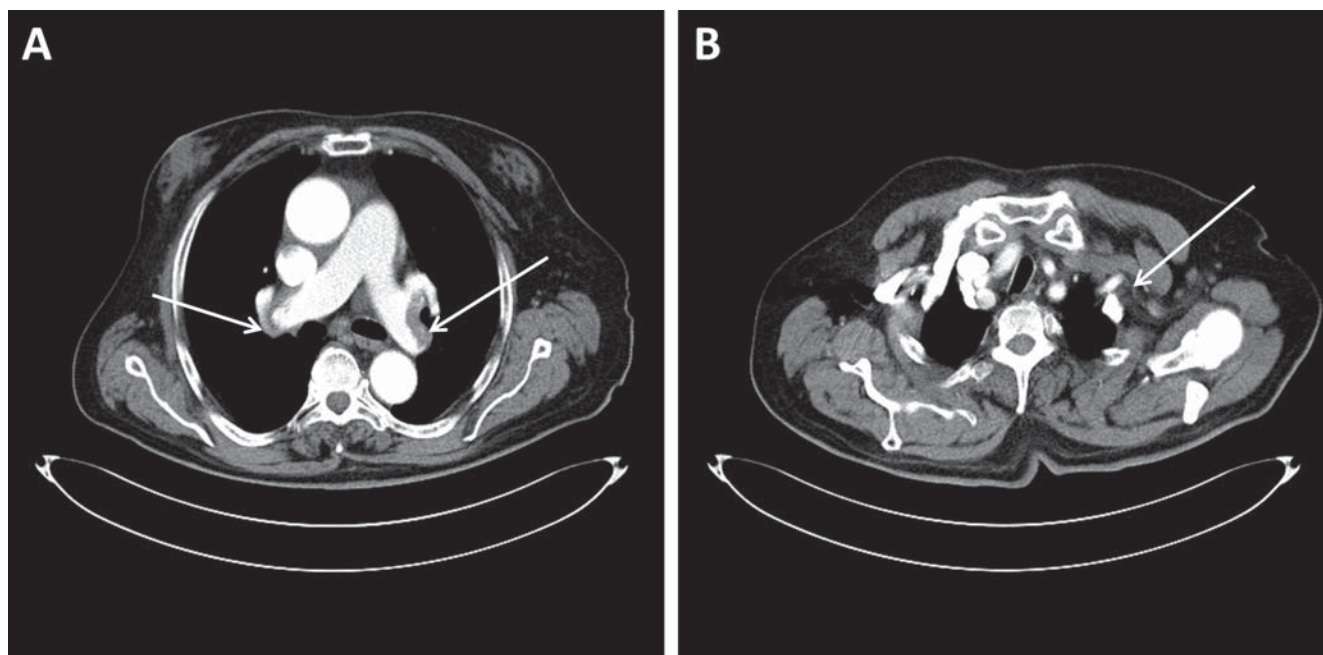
Computed tomographic angiography images of the chest showing (A) large emboli in both right and left pulmonary arteries (arrows) and (B) total occlusion of the left subclavian artery (arrow).
